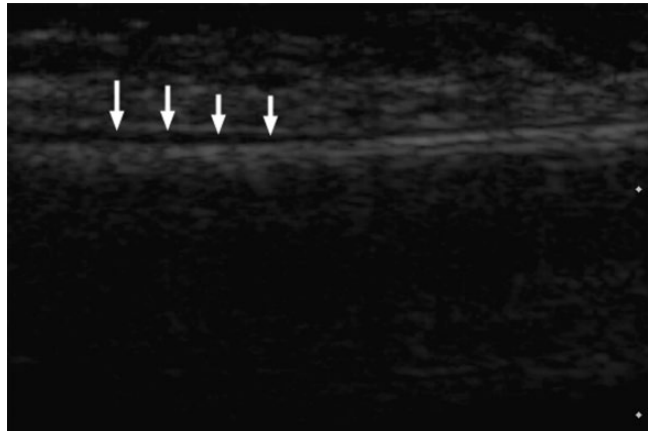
Typical image of bone on ultrasound. Note the bright echogenic cortical surface and the acoustic shadow.
